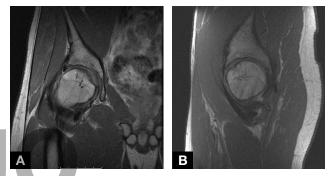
Case 1: 6-month postoperative coronal (A) and sagittal (B)  $T_1$ -weighted MRI of hip (Figure 2) shows incorporation of osteochondral autograft plug into surrounding host bone and rounded contour of femoral head articular cartilage.
